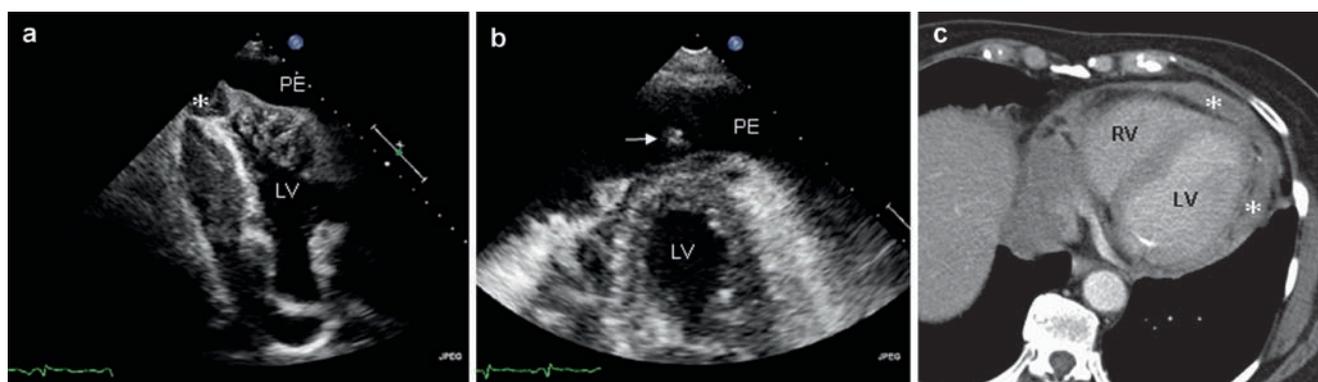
Secondary cardiac manifestation of a low-malignant non-Hodgkin lymphoma in a 77-year-old female patient. Transthoracic echocardiography shows massive intra-pericardial lymphoma growth with compression of the right heart chambers, as well as infiltrative growth into right ventricular apex (*asterisk*) (a). At the time of echocardiographic examination, cardiac lymphoma manifestation was unknown, and diagnosis of haemodynamically important pericardial
